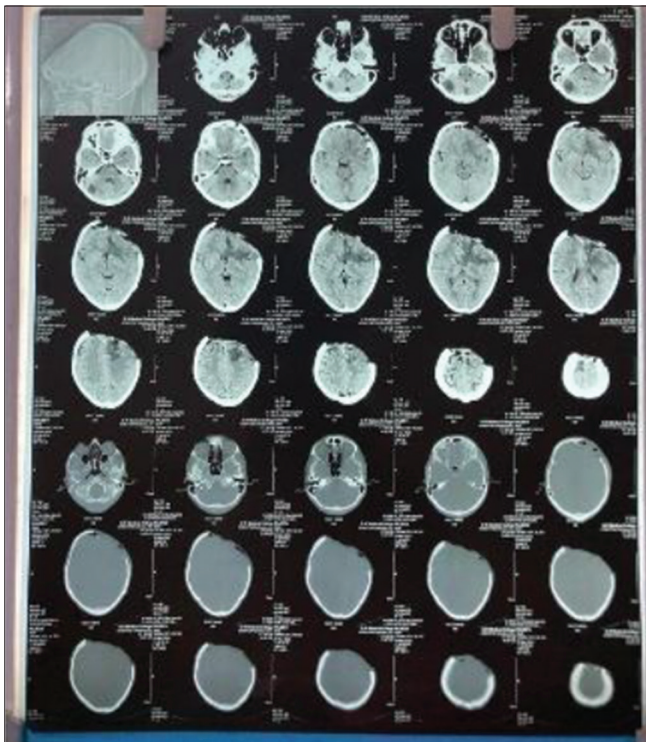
Post-operative non-contrast computed tomography head
